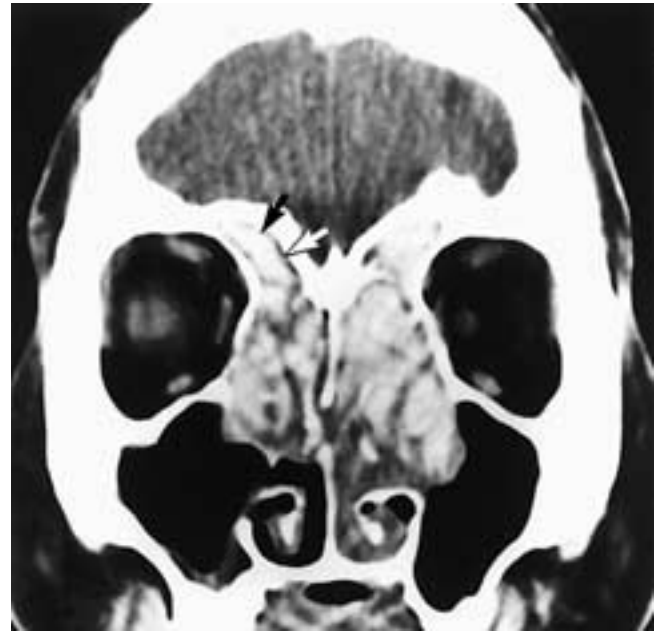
Coronal CT scan shows multiple high-attenuation soft-tissue masses extending from the ethmoid sinuses into the nasal fossae. Each polypoid mass is separated from the adjacent bone by a thin zone of mucoïd attenuation material (arrows). The polyps are also embedded within a matrix of mucoïd secretions. This patient had nasal and paranasal sinus polyposis.
